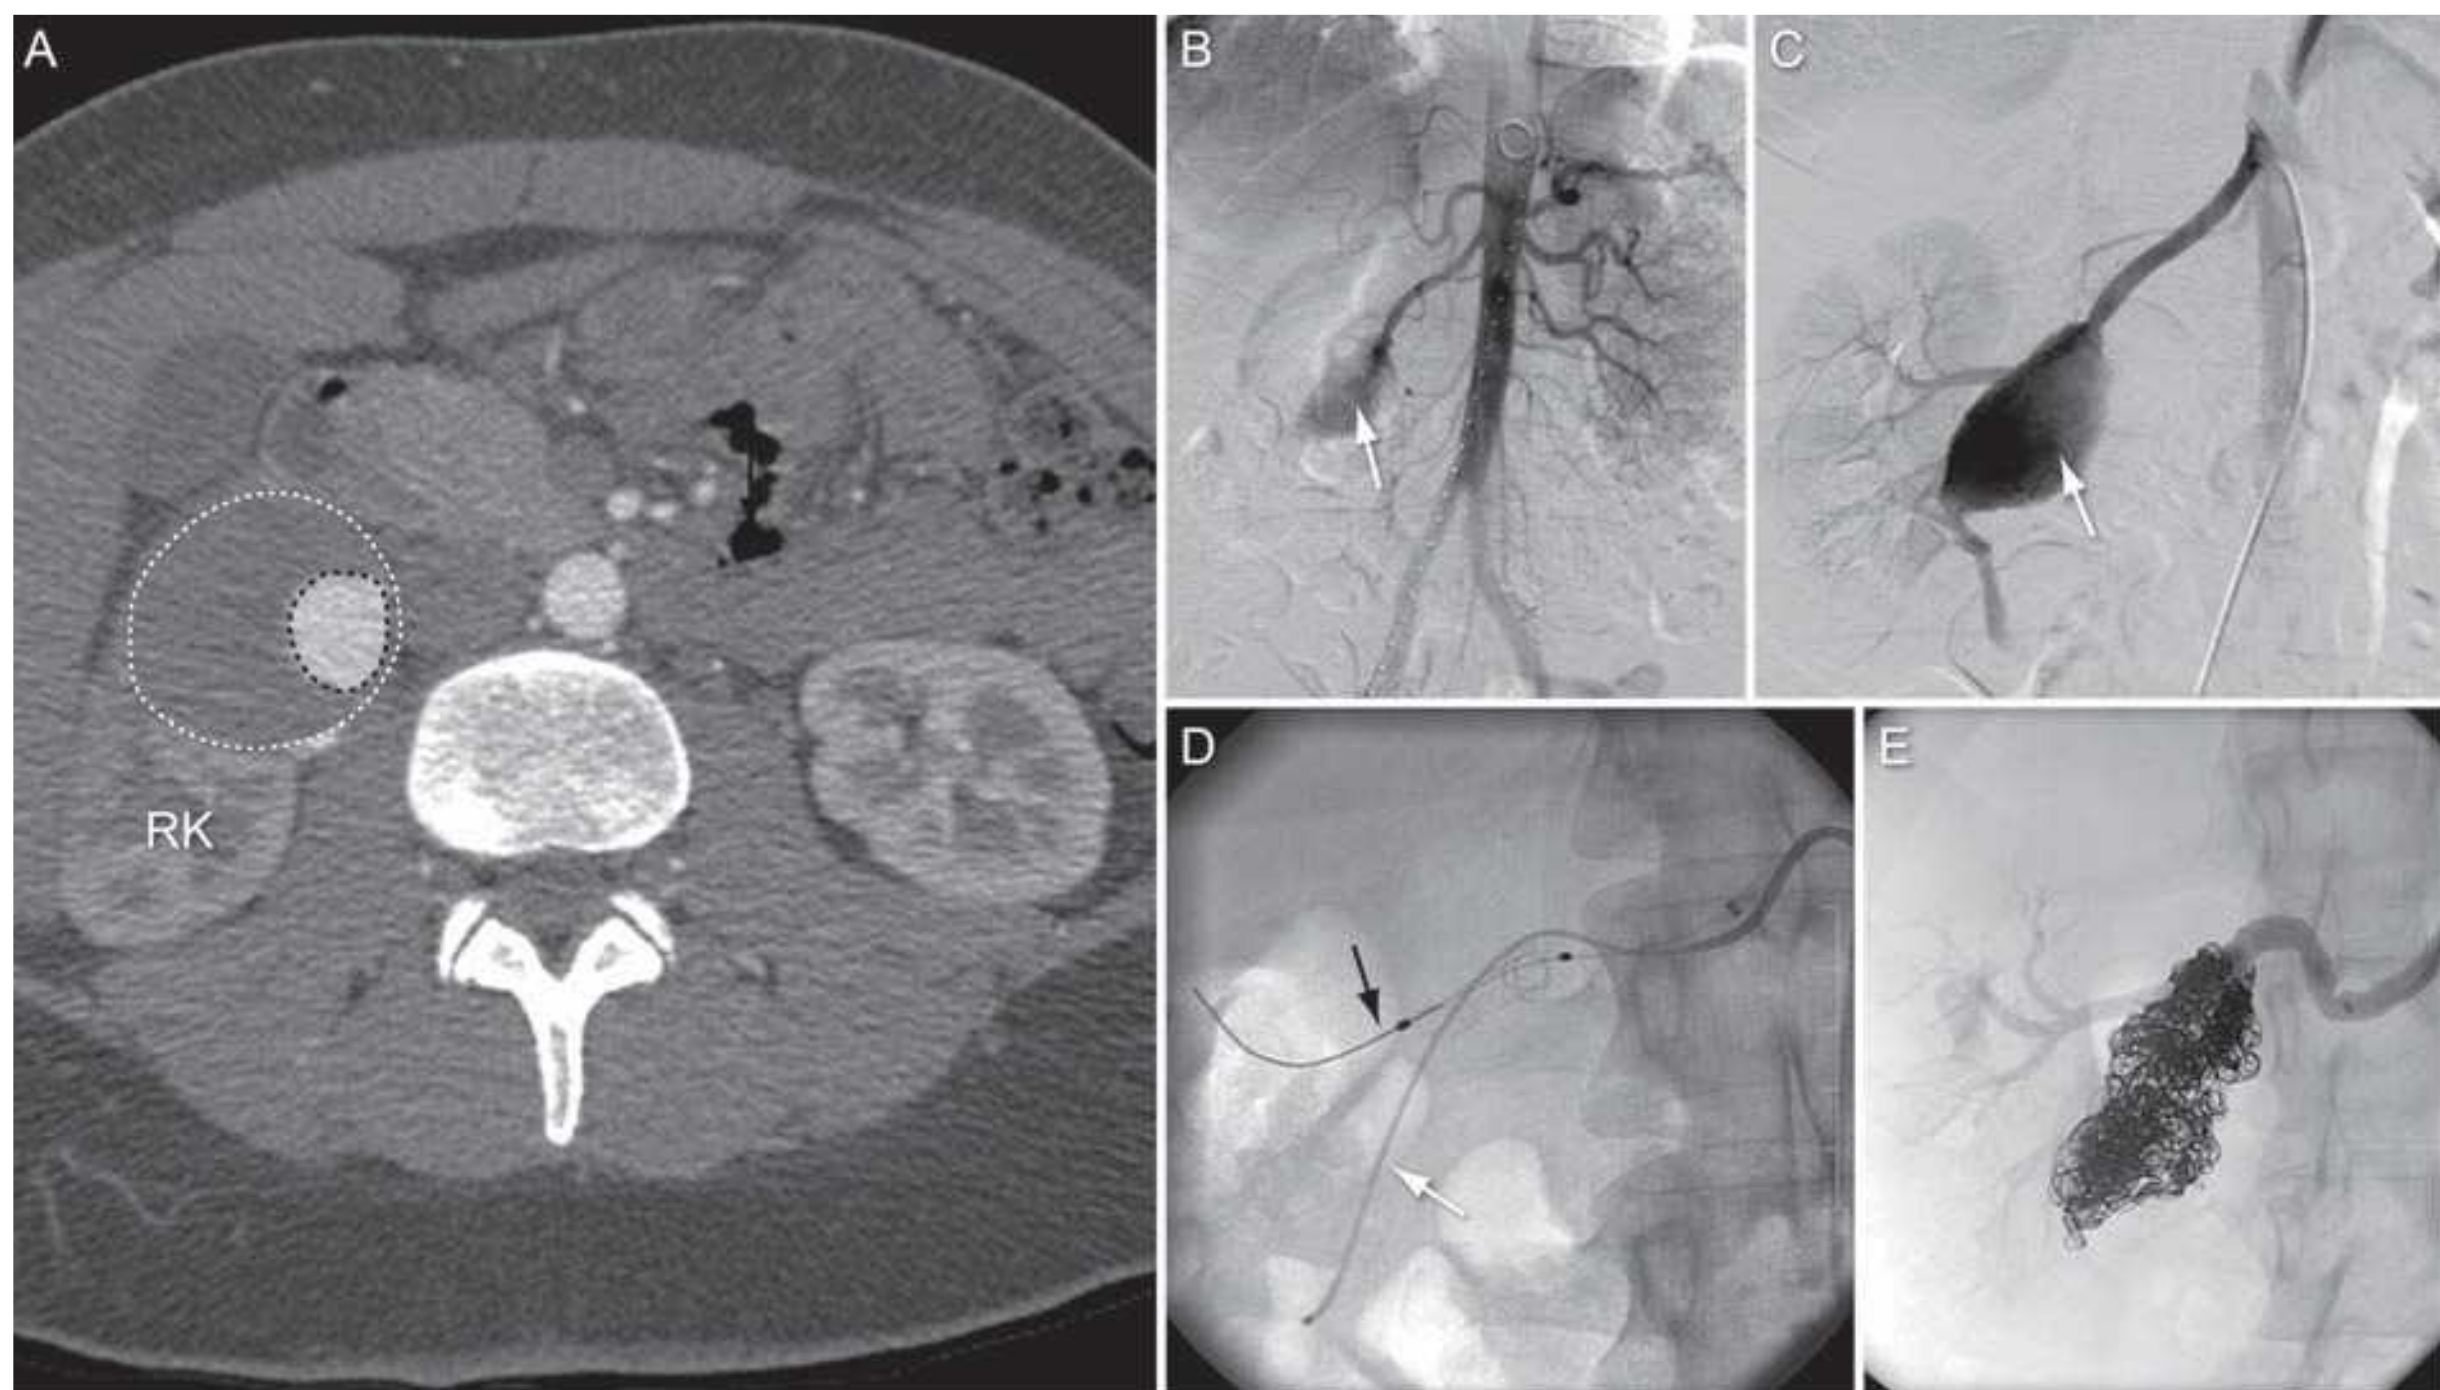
Endovascular repair of renal artery aneurysm. A: Computed tomography angiogram showing large aneurysm of right renal artery (outline of wall of aneurysm shown by *interrupted white line*). Contrast in lumen of aneurysm shown by *interrupted black line*. B: Preprocedural abdominal aortogram. C: Preprocedural selective right renal artery angiogram (aneurysm indicated by *arrow*). D: Following dual arterial access, stent-assisted coil embolization of the aneurysm was performed. *Black arrow* indicates wire in renal branch to be preserved. *White arrow* indicates wire in aneurysm sac. E: Completion angiogram showing successful exclusion of the aneurysm.
